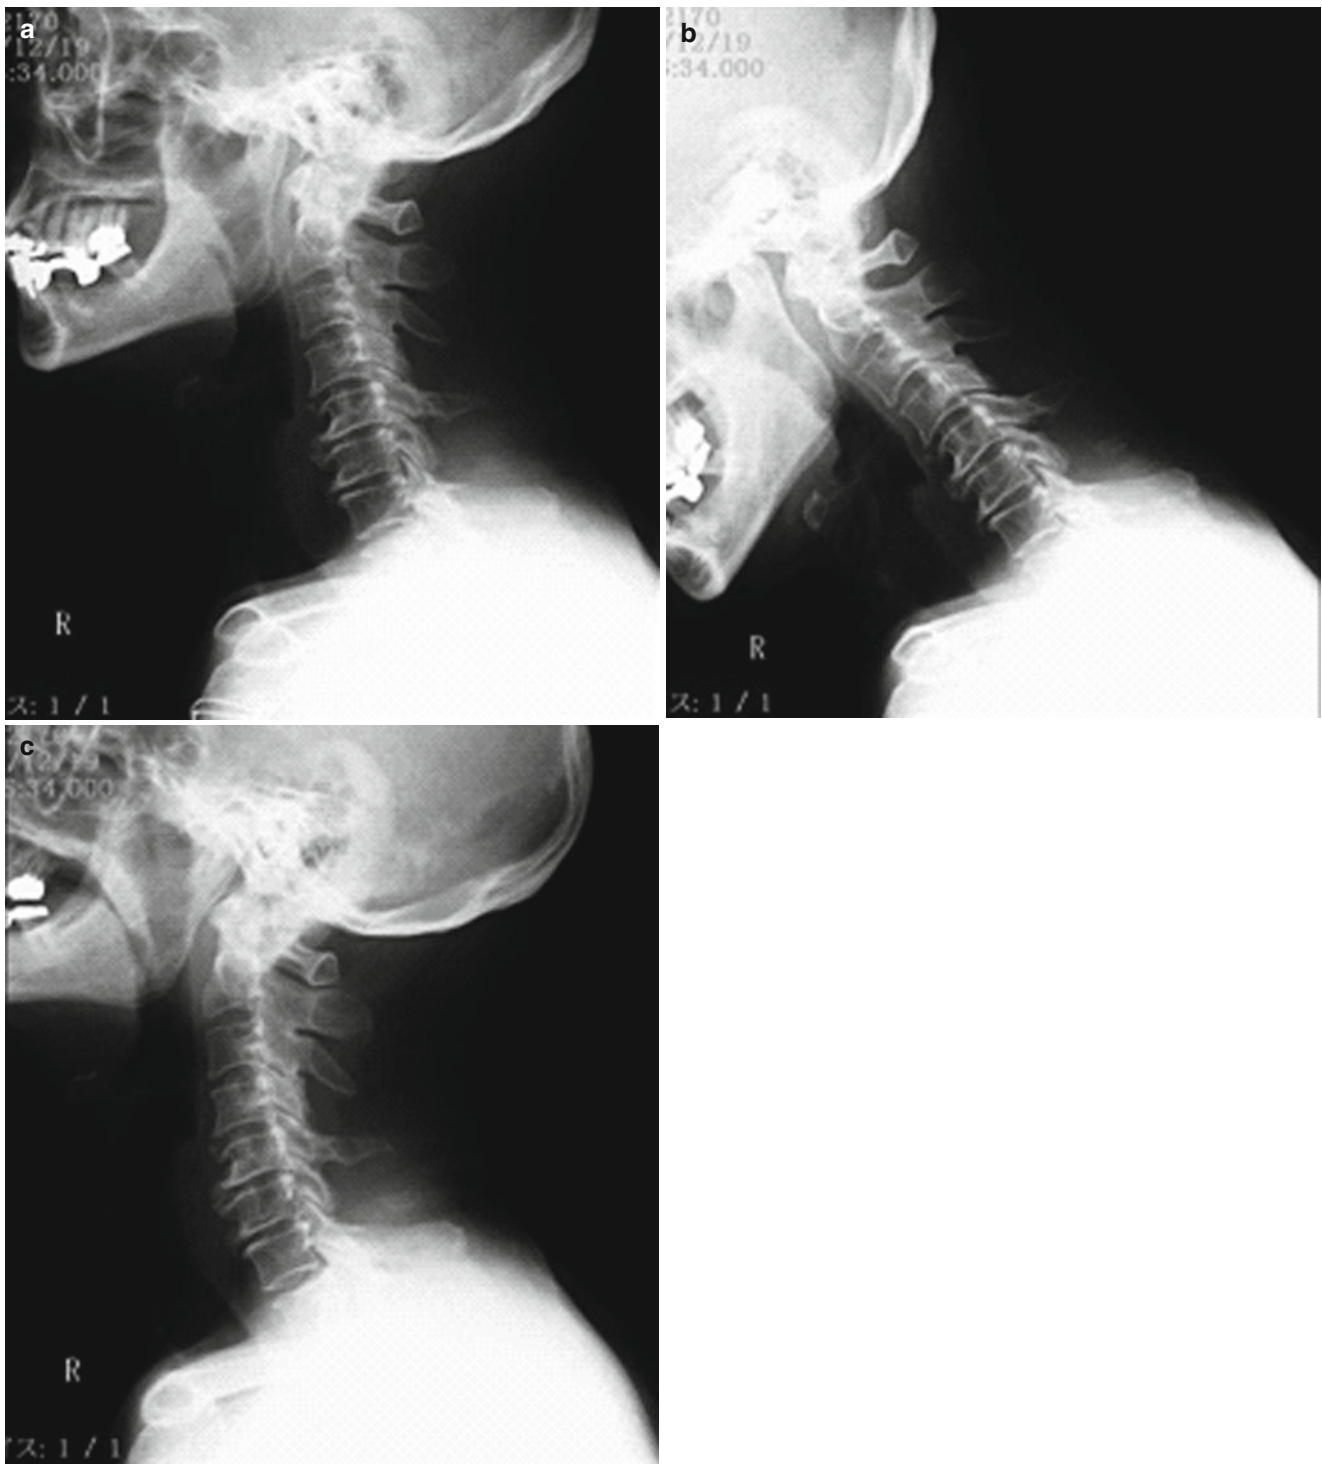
(a–c) Cervical X-rays at 1 year postoperative demonstrate a maintenance of cervical lordosis with no loss in range of motion
